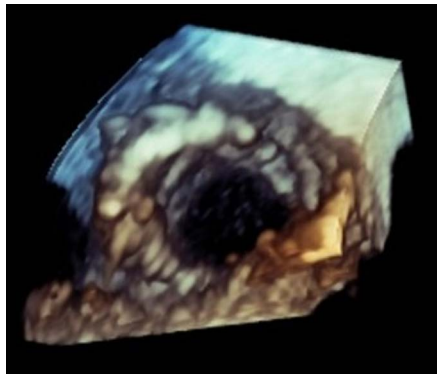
Transoesophageal echocardiography with 3-dimensional rendering post-implantation showing a functional valve and no orifice stenosis.
